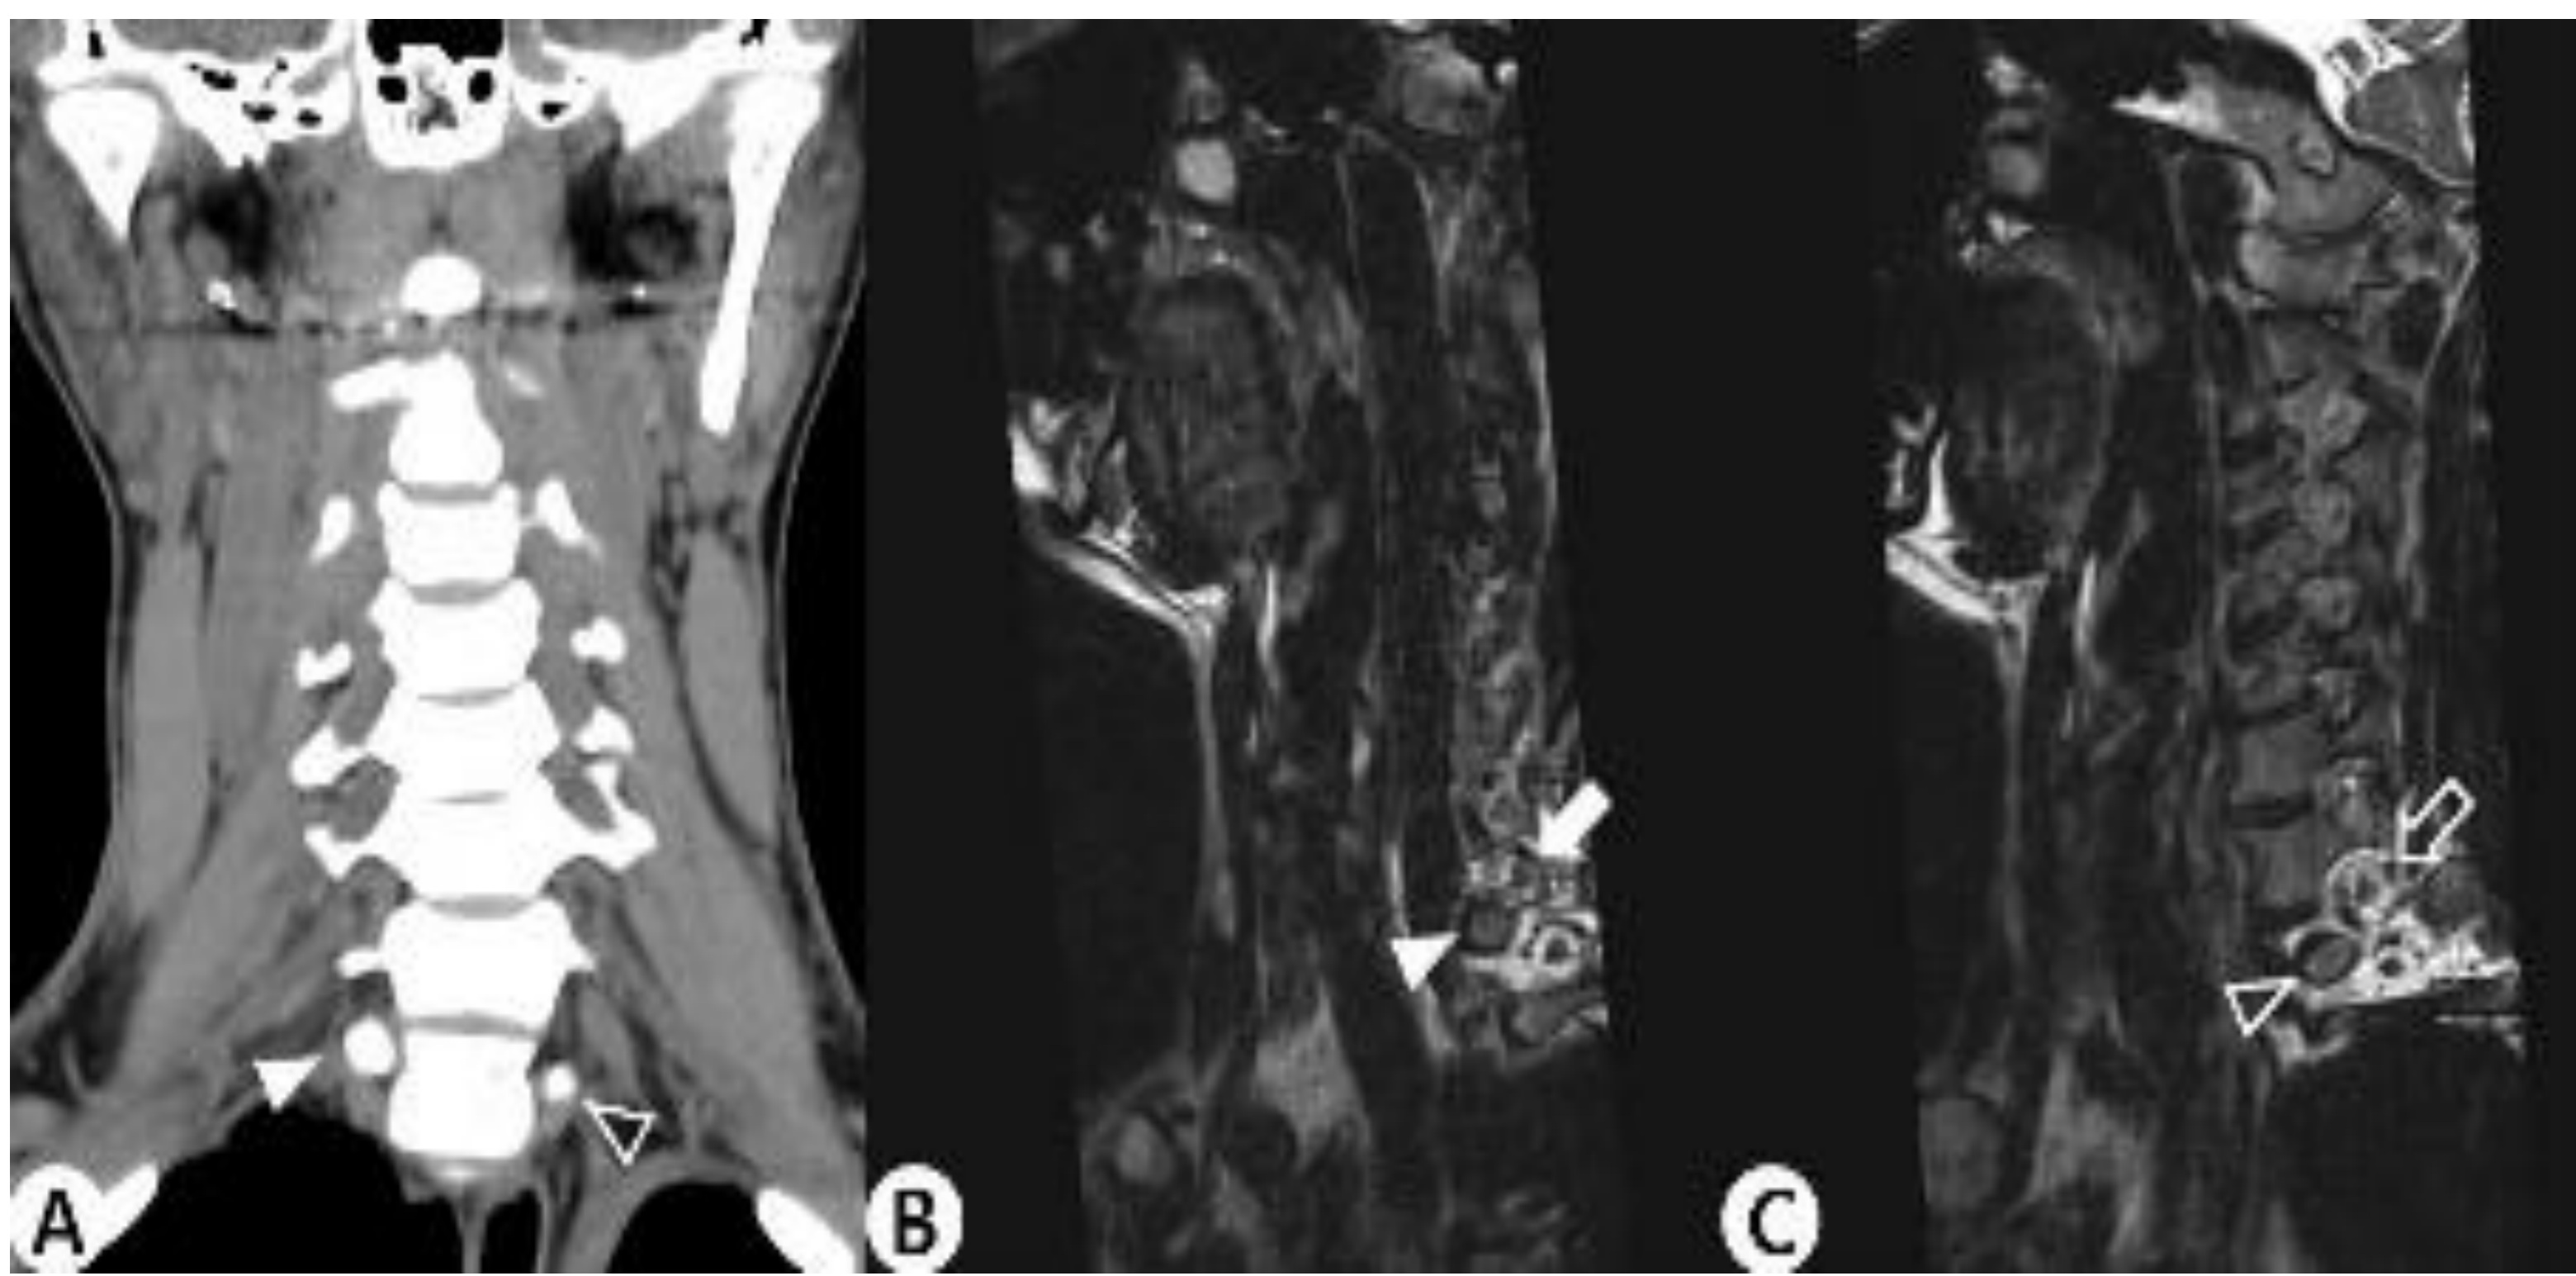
(A) Coronal CT image shows the right 1st rib (white arrowhead) positioned higher than the left 1st rib (empty arrowhead).
